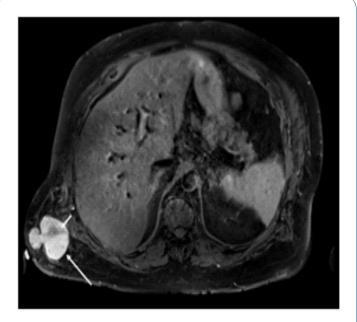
Precontrast T1-weighted fat saturated image reveals the mushroom shaped mass in the posterior chest wall (long arrow) with hypointense central signal (short arrow).
